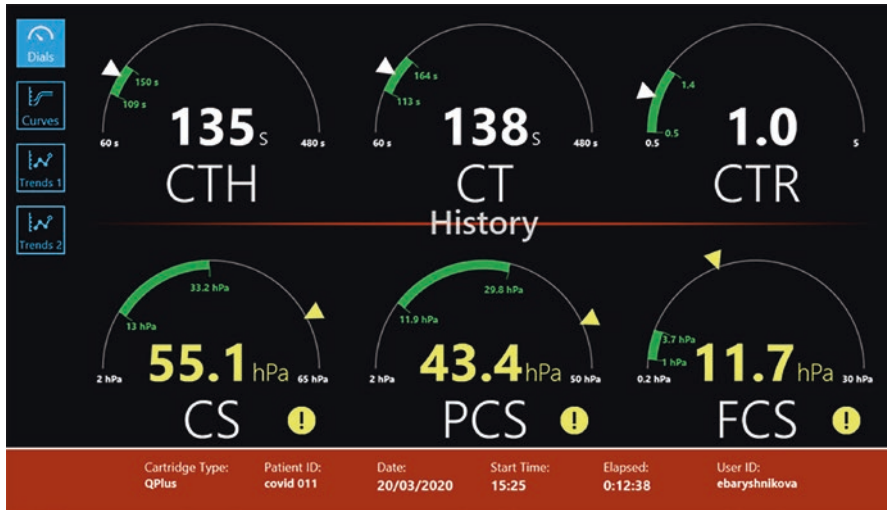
Typical Quantra tracing from a representative critically ill COVID-19-positive patient with a procoagulant pattern. Very high level of fibrinogen contribution to clot stiffness (FCS) is of note. On the dial view of the results, the green space represents the normal range and the yellow arrow indicates the position of the patient's value. The exclamation point stands for a value out of normal range and worth of the operator's attention. Abbreviations: CT, coagulation time; CTH, coagulation time with heparinase; CTR, coagulation time ratio; CS, clot stiffness; PCS, platelet contribution to clot stiffness; FCS, fibrinogen contribution to clot stiffness
